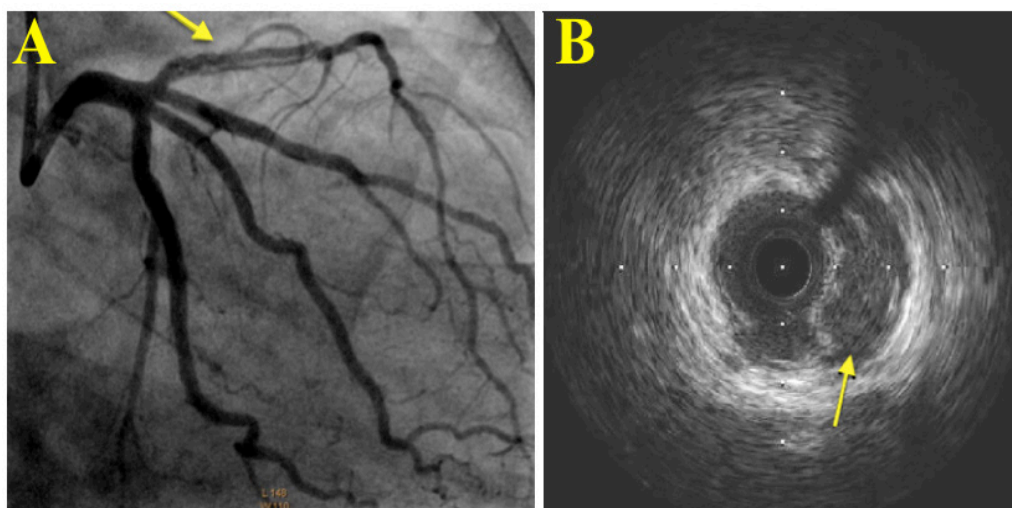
A - Coronary angiography of left coronary showing dissection in the proximal and medium third of left anterior descending artery (arrow). B- Intracoronary ultrasound showing double-lumen sign in the left anterior descending artery (arrow).
